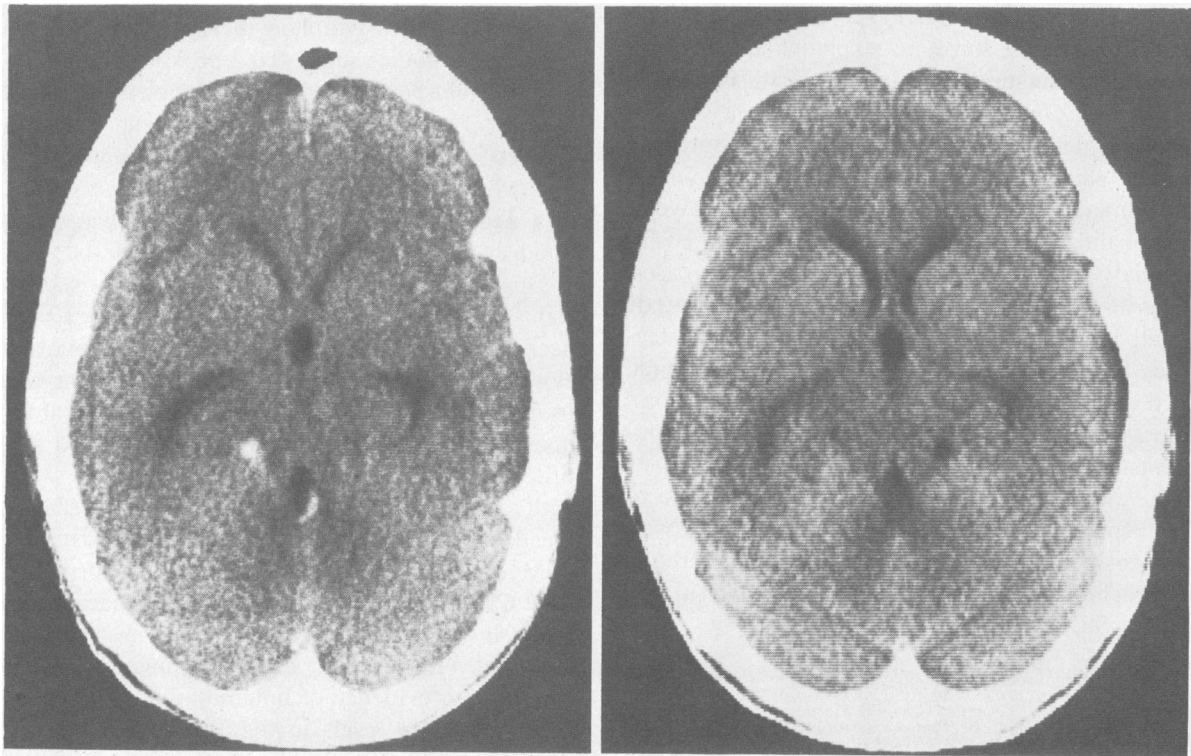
Computerized tomography (CT) scan of 21-year-old Laotian man with gnathostomiasis shows presence of subarachnoid blood in the right ambient cistern and roof of fourth ventricle eight days after the onset of symptoms (left). CT scan done one week later shows the clearing of blood from these spaces (right).
